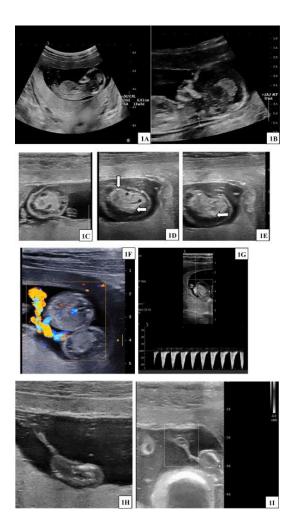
(A and B) showing normal twin with a crown rump length corresponding to 13 weeks 3 days normal nuchal translucency for gestation age. Figure (C, D, & E) showing an amorphous solid cystic mass (white arrow in figure C & D) separate from the normal twin measuring approximately 2.4×2.1 cm in size. Umbilical vein, liver (star in Fig. D) along with few echogenic bony structures were noted within the amorphous mass (white arrows in Fig D & E) suggesting amorphous acardiac twin. Figure (F and G) showing color and spectral Doppler images of the amorphous mass with surface vascularity near the attachment site of umbilical cord which on spectral (Fig G) Doppler showed persistent reversed flow in the umbilical artery. Figure (H and I) Subsequent USG done after 1 month showed reduction in size of the acardiac twin $(1.8 \times 1 \text{ cm})$ with absence of flow within umbilical cord on color Doppler (Fig I).
